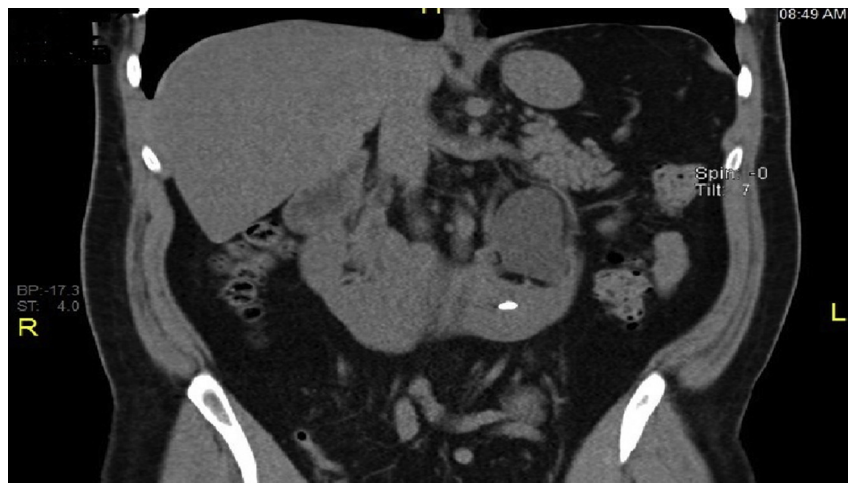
CT KUB, lower calyx stone.
